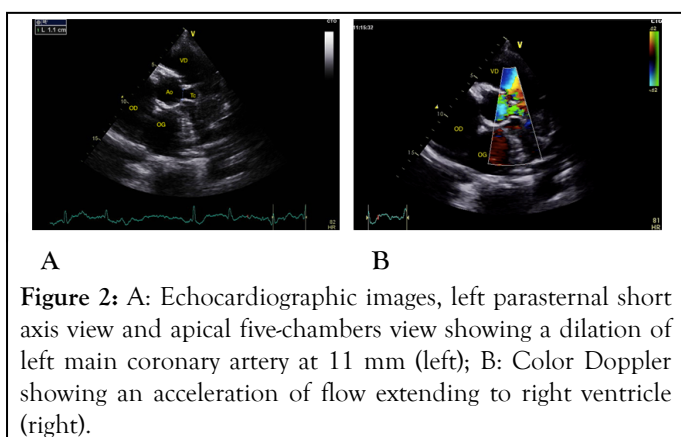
A: Echocardiographic images, left parasternal short axis view and apical five-chambers view showing a dilation of left main coronary artery at 11 mm (left); B: Color Doppler showing an acceleration of flow extending to right ventricle (right).
